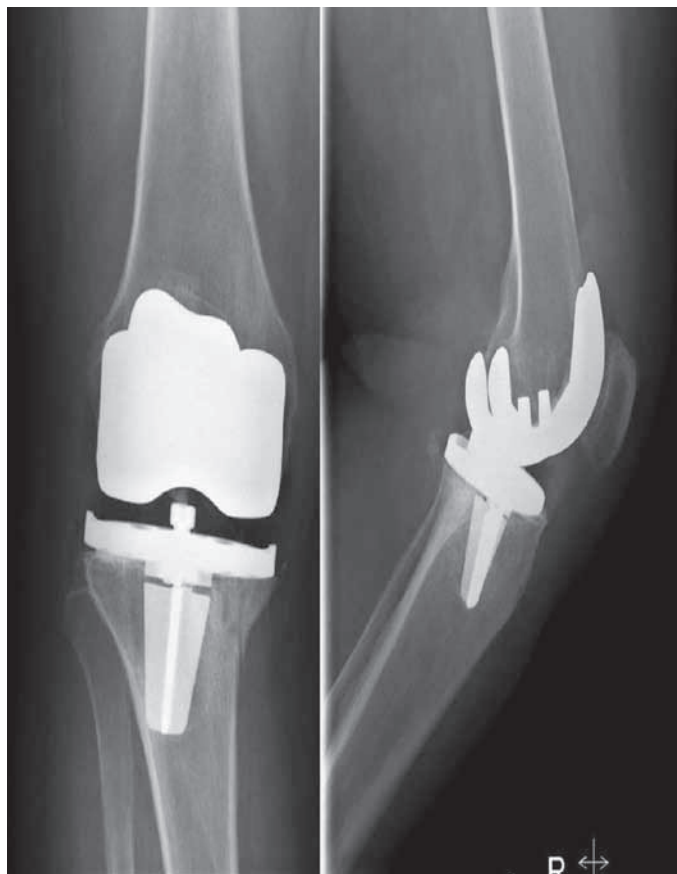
X-ray upon admission.
